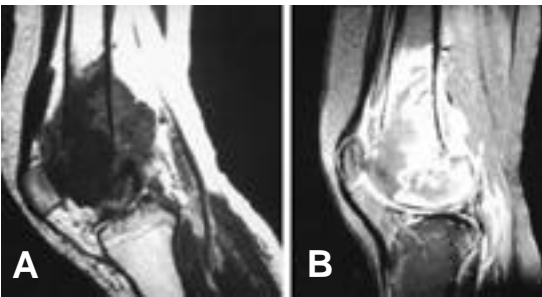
MRI shows decreased tumor size and peritumoral edema before (A) and after (B) chemotherapy.
